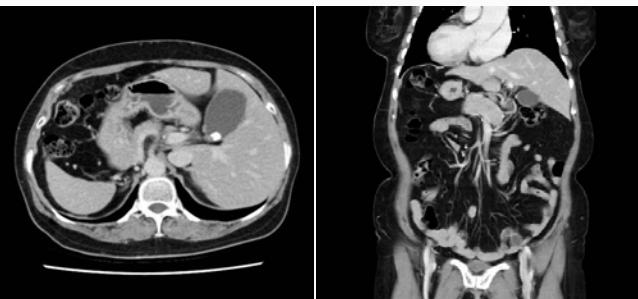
Computed tomography disclosing complete transposition of the abdominal viscera (A) coronal view and (B) axial view.
